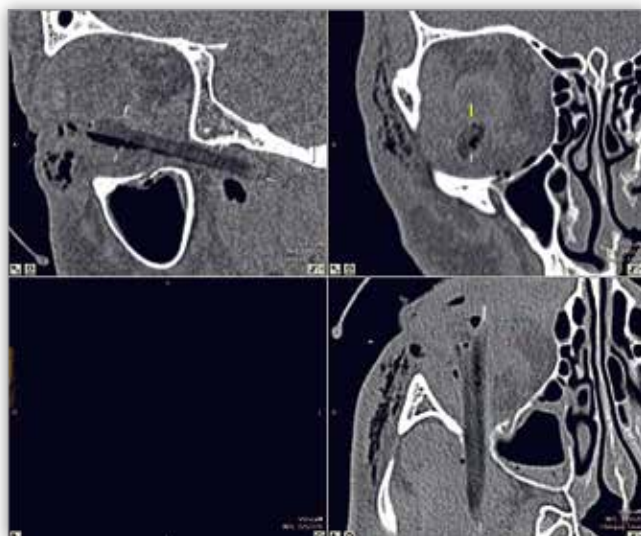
Preoperative CT enabled accurate assessment and measurement of the foreign body.
